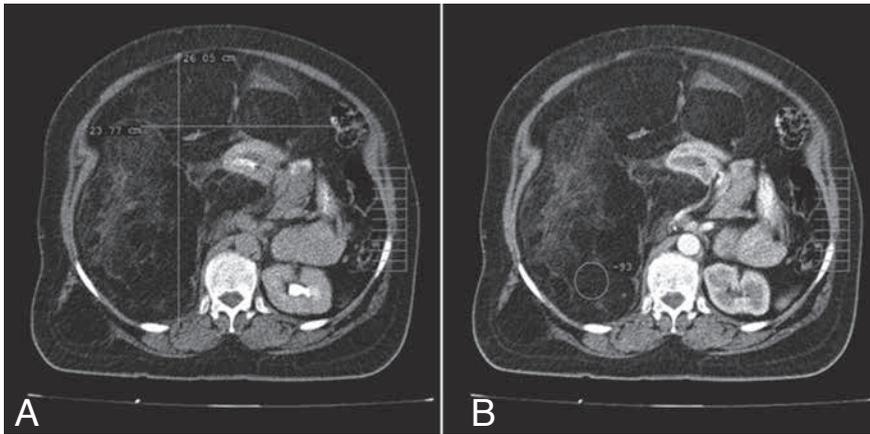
Noncontrast (A) and contrast-enhanced (B) CT images show a large fatty mass which is filling a very big portion of the abdominal cavity and displacing right kidney to medially and ventrally.
